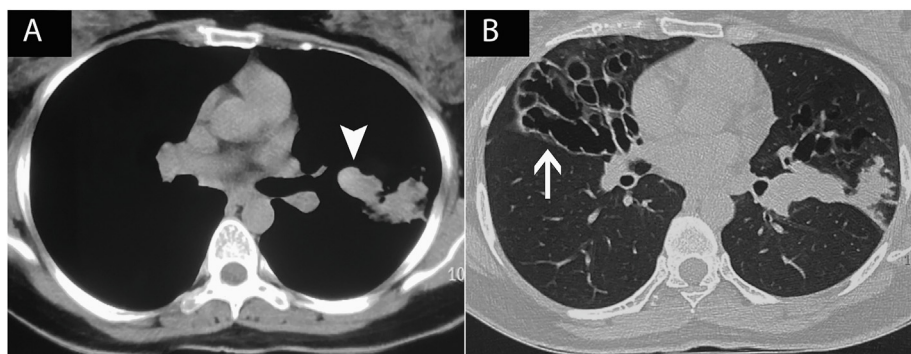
Computed tomography of the thorax of a patient with allergic bronchopulmonary aspergillosis shows mucus impaction in subsegmental airways (panel A, mediastinal windows). There is the presence of high-attenuation (arrowhead) mucus. Corresponding lung windows (panel B) show the presence of bronchiectasis (arrow) besides the mucus-filled bronchi.
